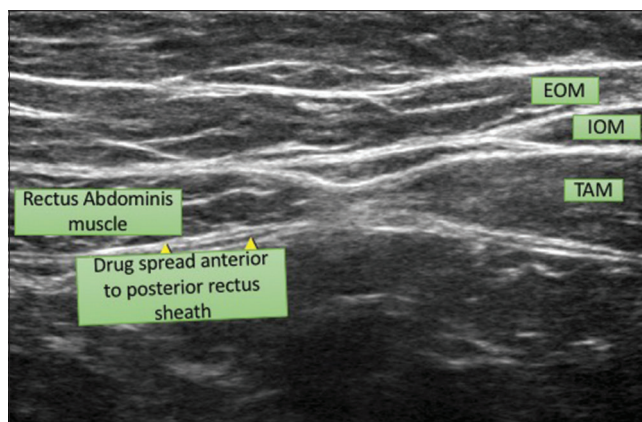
Ultrasound-guided RSB (EOM—External Oblique muscle, IOM—Internal Oblique Muscle, TAM—Transversus Abdominis Muscle)
